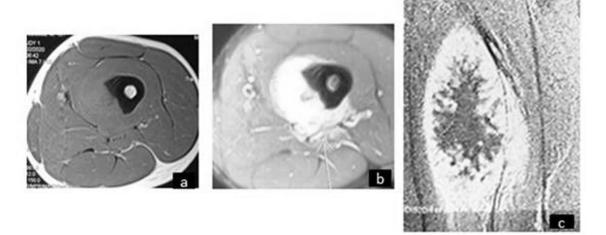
MRI demonstrated a sharply delineated mass at the bone surface, it had a iso- signal on T1 weighted (a), a bright signal on T2 weighted STIR, (b), slight peripheral and septal enhancement after Gadolinium injection (c: Sagittal contrast-enhanced T1-weighted), without intramedullary extension
